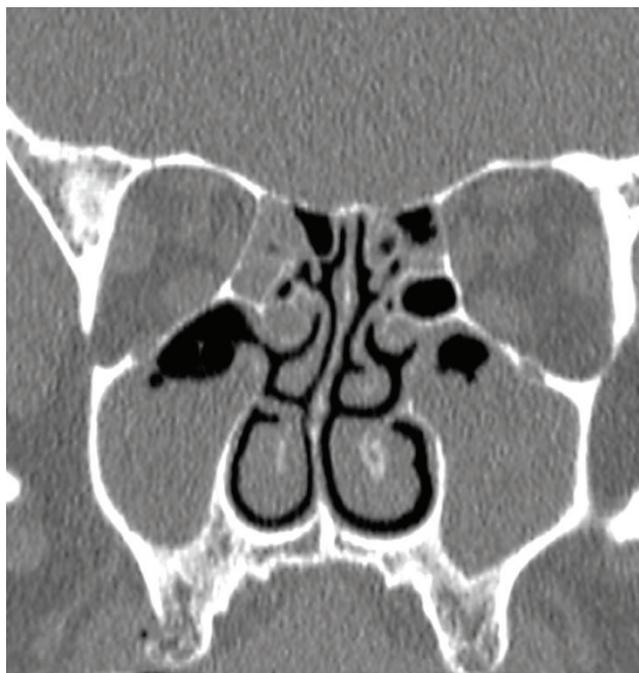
Lund-McKay Grade 2 (Both Maxillary sinus) with Grade 1 (Both side ethmoidal) Sinusitis. This case had a total score of 9 and 11[2]. A total of 63 cases underwent Computed tomography scan of Para-nasal Sinuses for confirmation of Sinusitis or due to ambiguity of diagnosis.
